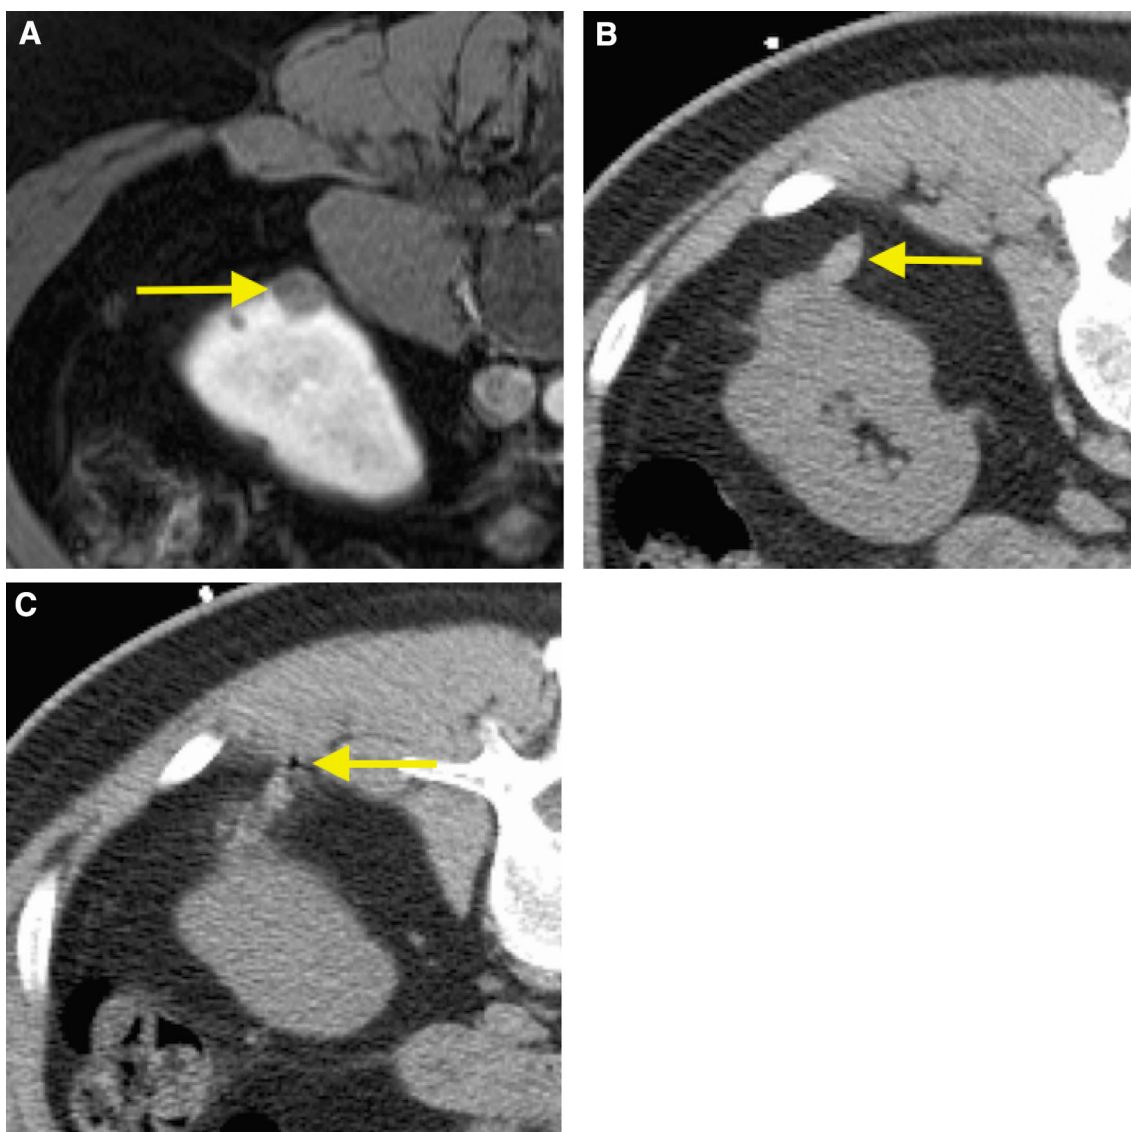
Separate session renal mass biopsy for a 64-year-old man with a small renal mass. Axial enhanced T1-weighted, fat-saturation MRI of the abdomen (A) with the patient prone demonstrates a partially exophytic small renal mass (≤ 4.0 cm) arising from the lower pole of the right kidney (*arrow*). At US-guided biopsy, the mass became obscured after the first pass, due to intratumoral bleeding, a perinephric
